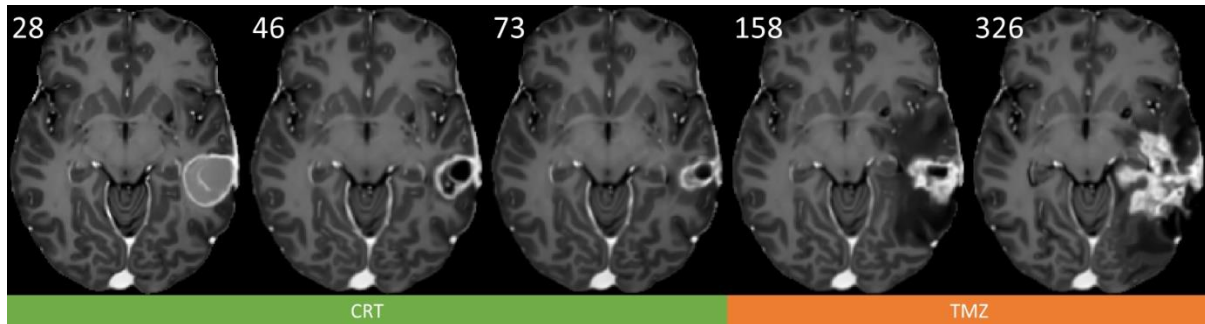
Time-lapse of contrast enhanced T1w MRI of standard treatment of glioblastoma with infiltrative recurrence. A 47-year-old male with confirmed glioblastoma received stereotactic surgery for removal of most of the tumor tissue at day 0 (not shown). About four weeks later (day ~28), the post-surgical cavity in the left temporal lobe was visible and surrounded by contrast enhancement of excess or new tumor tissue. Repeated chemoradiotherapy (CRT) and imaging presented shrinkage of the tumor cavity and surrounding regions (days 46 and 73 at completion of CRT). Then following chemotherapy with temozolomide (TMZ) only presented images with infiltrative recurrence with edema (day 158) and with contrast enhancement (day 326). Some tissue deformations were also seen in subcortical regions such as the basal ganglia and midbrain. Overall survival for this patient was around 16 months (480 days). This is subject nine from our second cohort (SAILOR, MRI 1,2,4,6,8).
